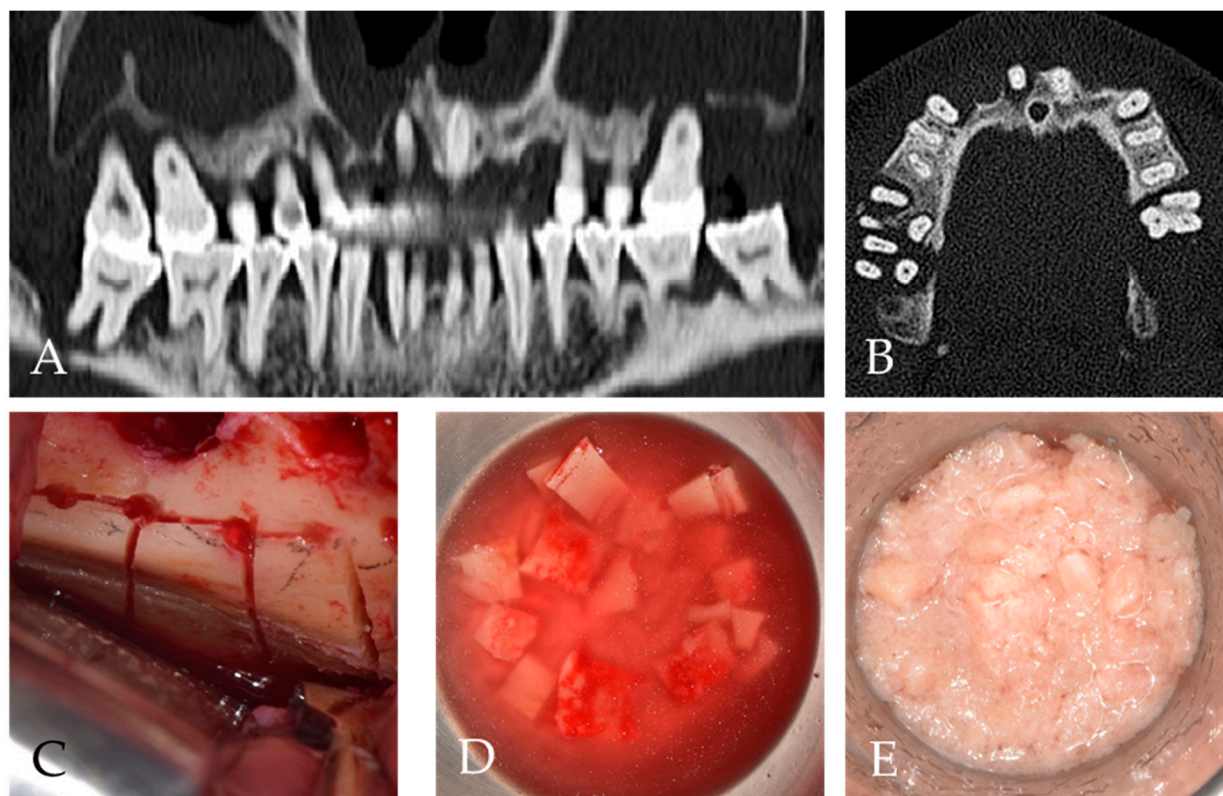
(A,B) Pre-operative radiographs showing generalized severe periodontitis and residual bone loss in the maxilla, with both sinusitis and oroantral fistulae. (C,D) Simultaneous surgery with the extraction of hopeless teeth; the autogenous bone was harvested from the lateral ramus. (E) The autogenous graft was crushed.
